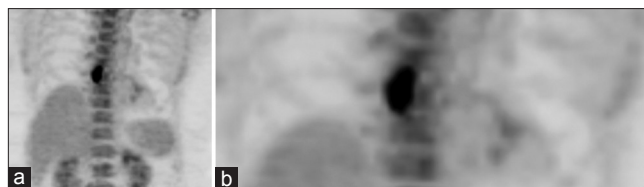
(a) Regional flurodeoxyglucose (FDG) positron emission tomography-computed tomography (PET-CT) of the chest done on another day after 4 hour external warming and intra venous injection of a standard dose of F18 FDG, demonstrates persistent intense FDG uptake with an standardized uptake value (SUV) max of 14.6, (b) Delayed time point PET CT of the chest was done 1 hour after the initial image post warming, demonstrating progressive increase in FDG uptake and SUV max of 16.2
